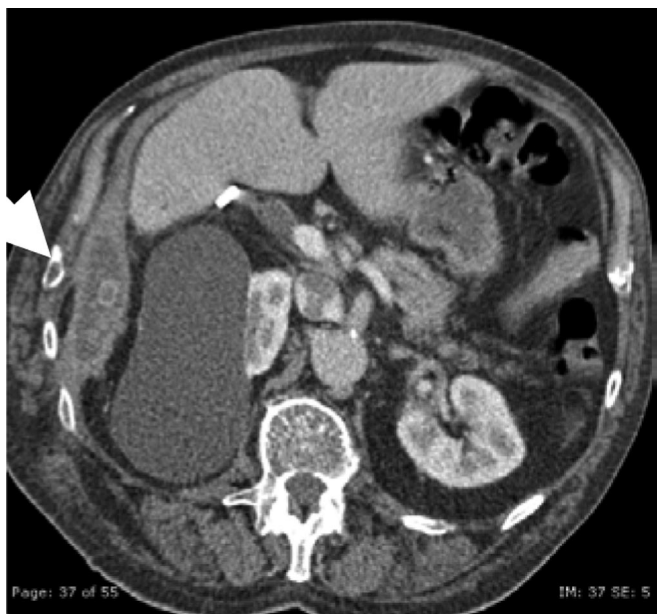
Computed tomography scan showing abscess cavity with several stones (with incidental renal cyst noted) in case 2. Arrow - abscess cavity containing gall stones.
